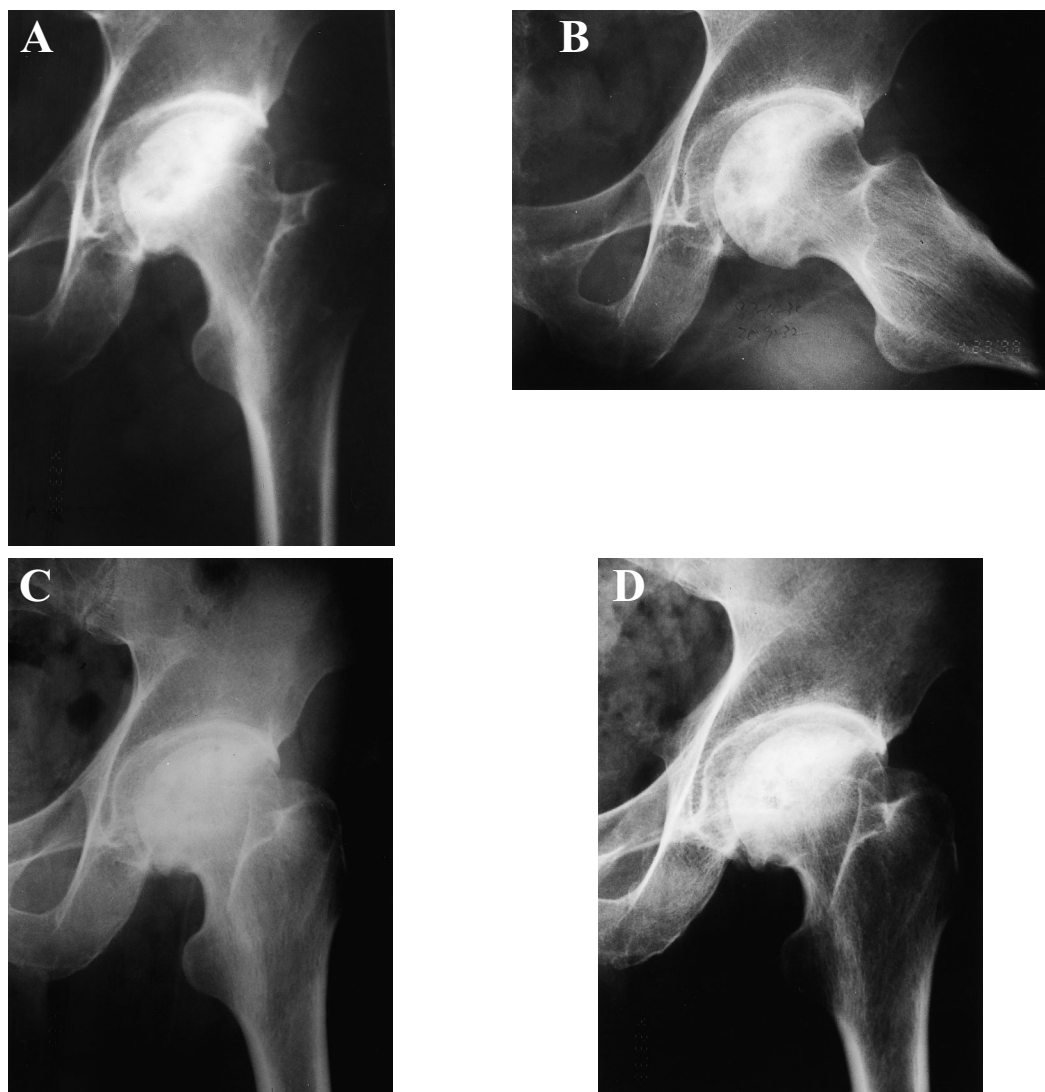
Remodeling of the osteonecrotic femoral head with delayed collapse of the femoral head. (A) ARCO stage IIC and Ohzono type IC on initial radiograph. (B) Frog lateral view of the same hip. (C) The osteonecrotic femoral head had remained spherical after 2 years. (D) Remodeling of the femoral head with some osteophyte formation shown 5 years after the first visit. The patient was free of symptoms.
